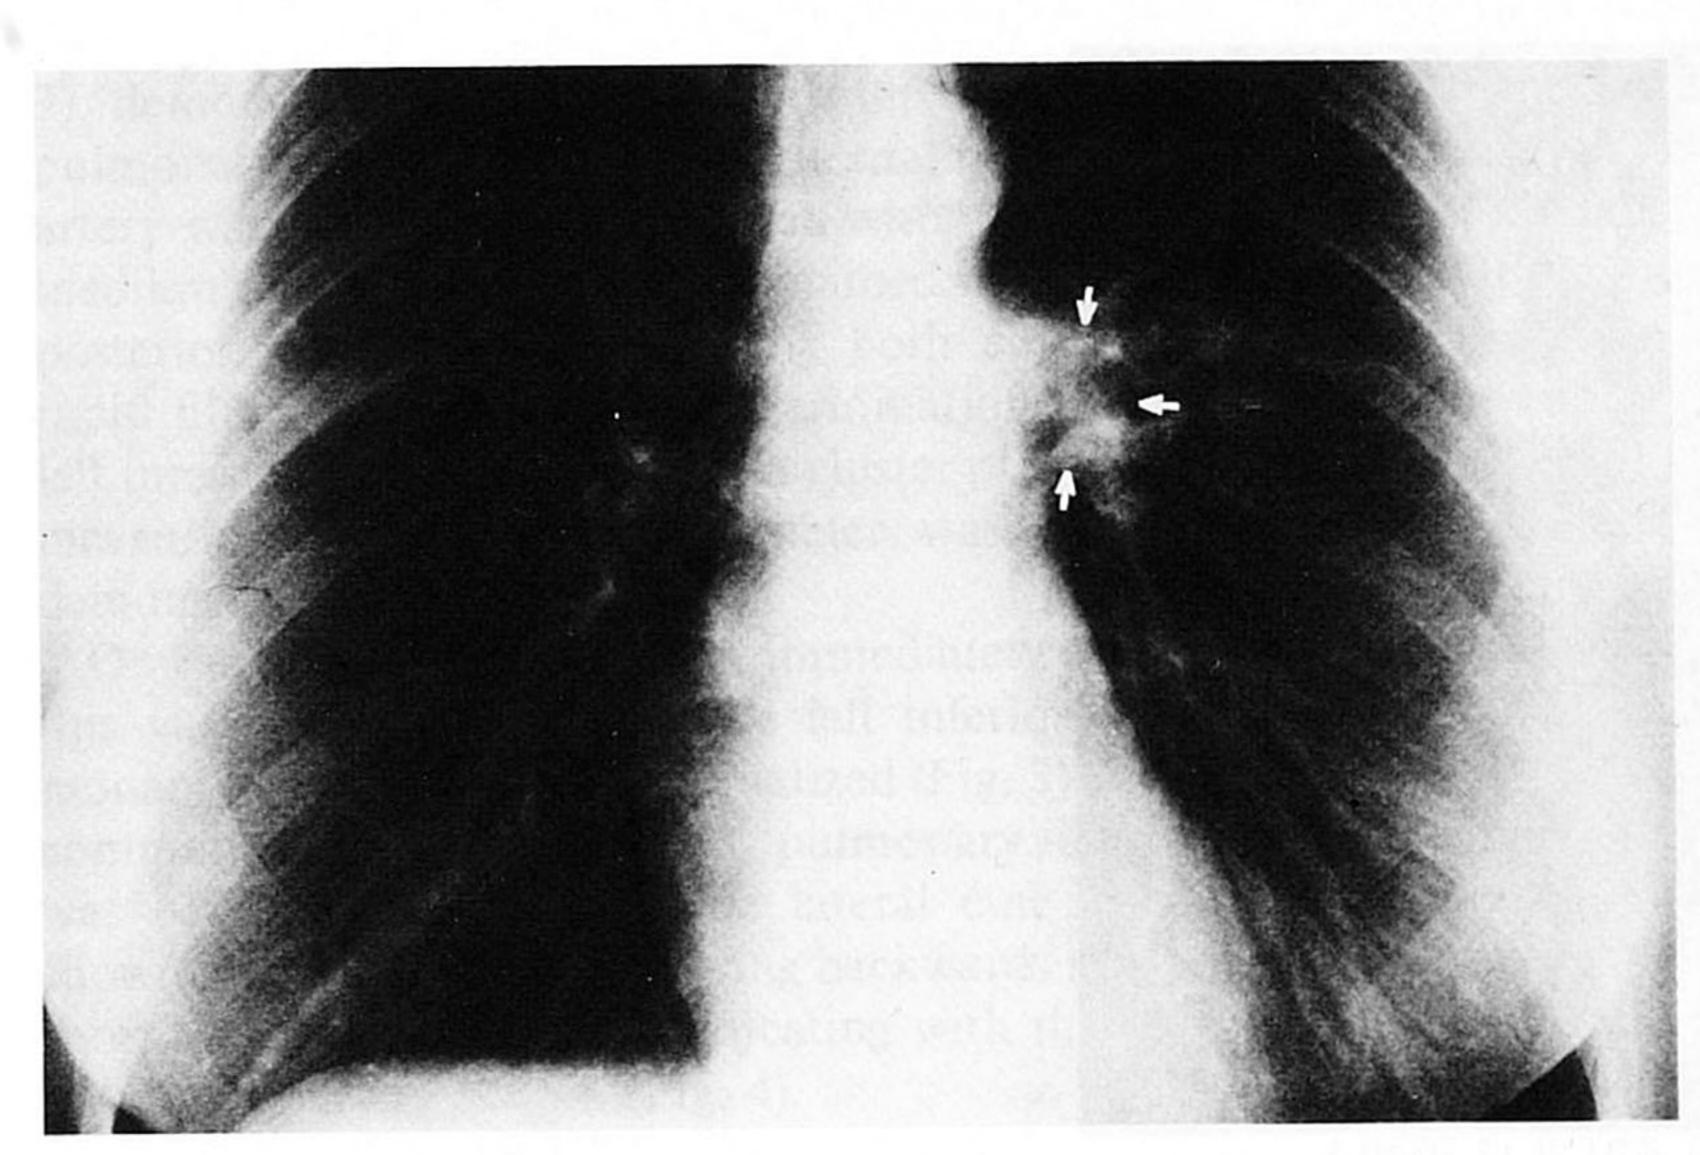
X-ray film of chest, antero-posterior view with dilated and nodular left hilum.
